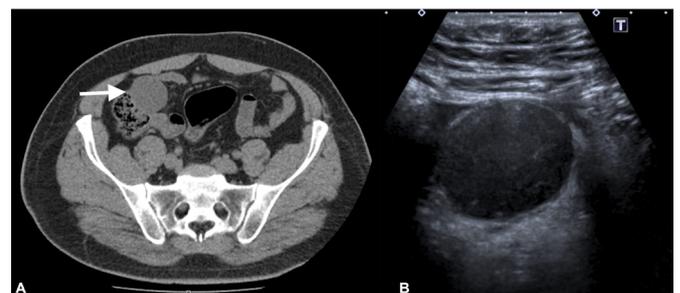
Axial CT (A) shows a blind-ending structure (arrow), consistent with a Meckel diverticulum. Right lower abdominal quadrant ultrasound (B) depicting a noncompressible blind-ending structure with regular inner mucosal margin, distended by fluid. The appendix is not visualized.
